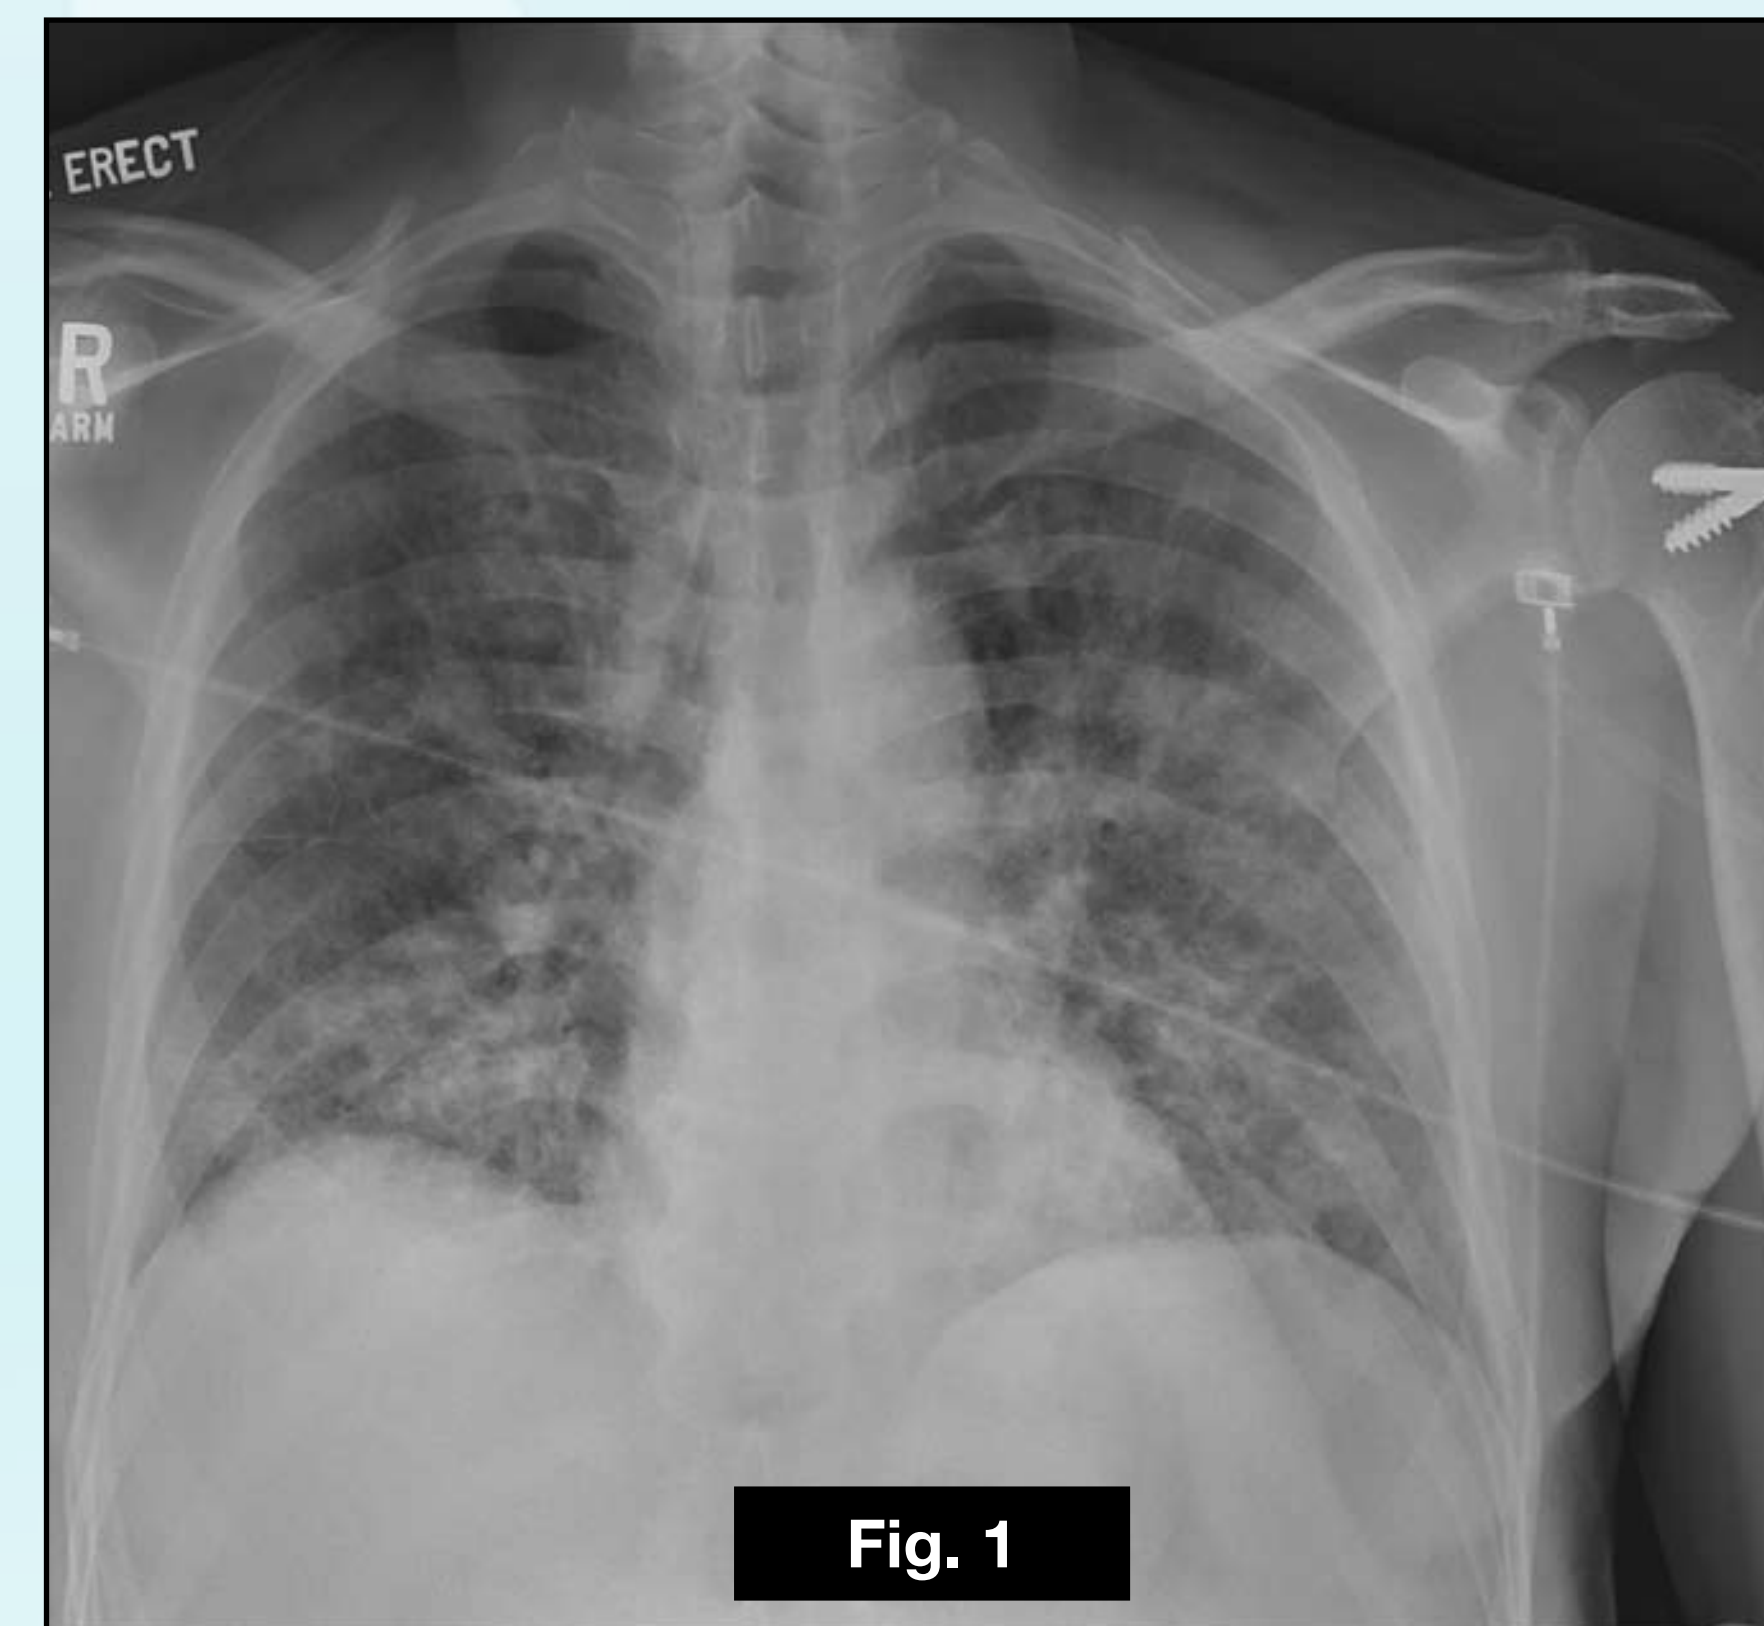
Initial chest X-ray showing bibasilar interstitial infiltrates.
